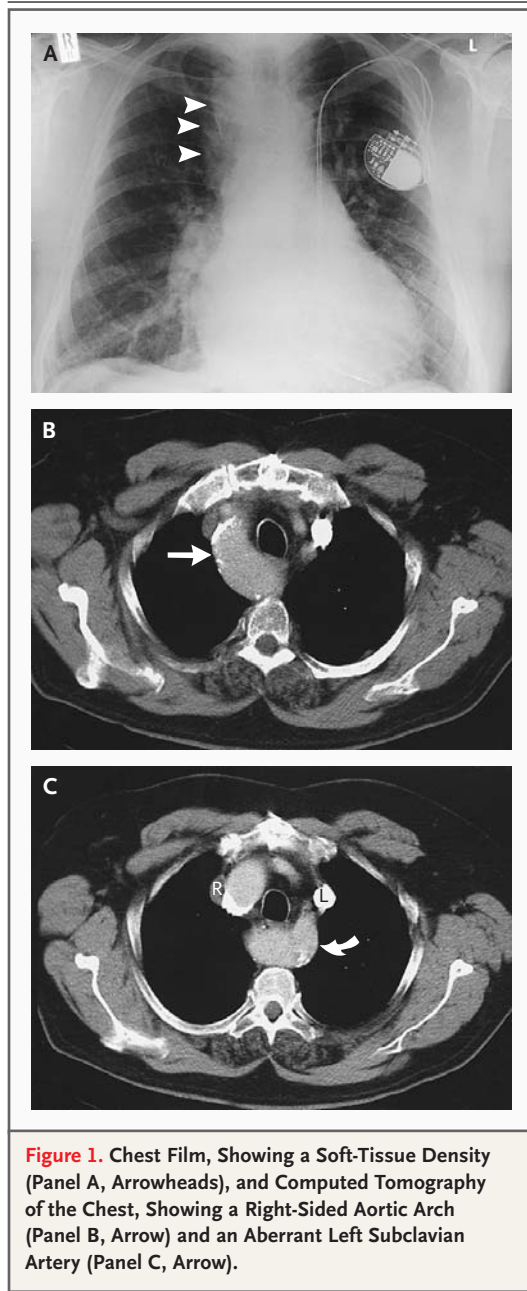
Chest Film, Showing a Soft-Tissue Density (Panel A, Arrowheads), and Computed Tomography of the Chest, Showing a Right-Sided Aortic Arch (Panel B, Arrow) and an Aberrant Left Subclavian Artery (Panel C, Arrow).
